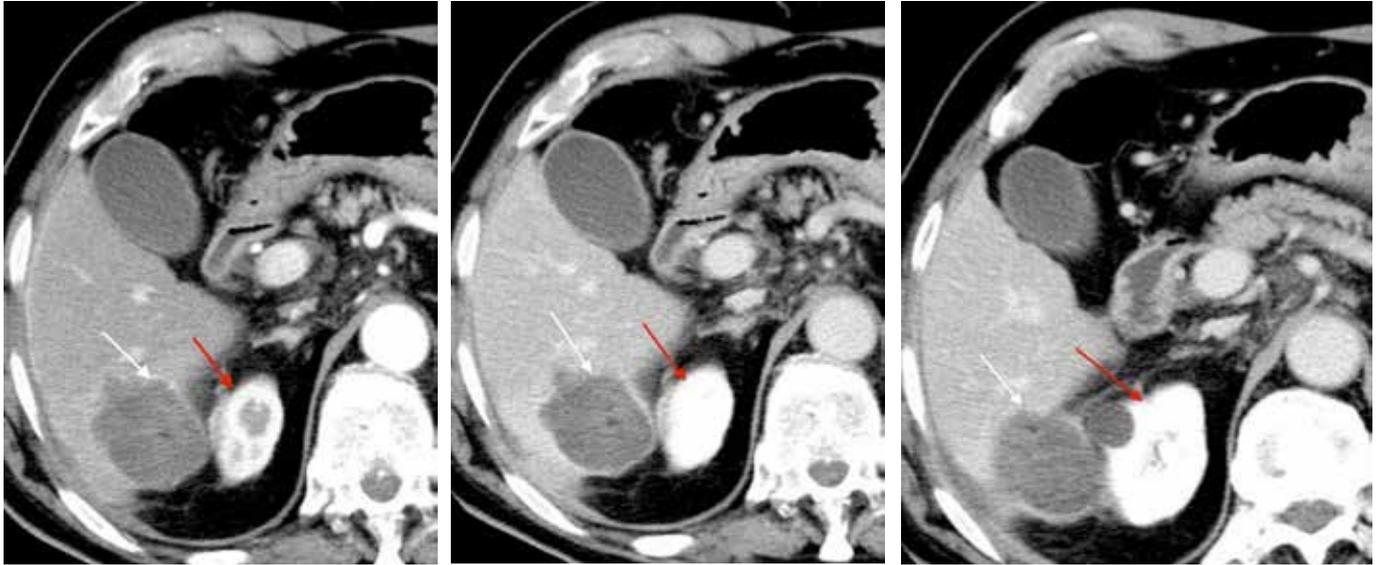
CT images after the treatment
